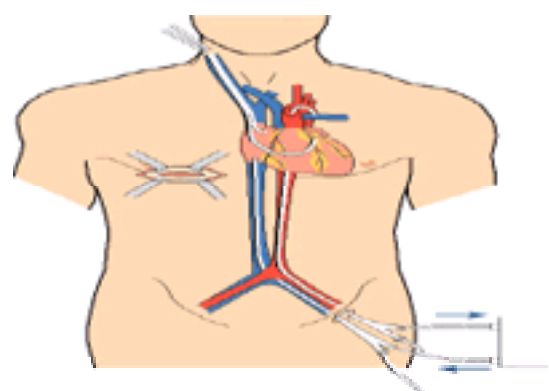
Port access (Heartport) approach for minimally invasive mitral valve surgery. This technique uses endoaortic clamping, retrograde cardioplegia delivery via a coronary sinus catheter, and a cardiac vent in the pulmonary artery, all positioned fluoroscopically or by transesophageal echocardiography.
